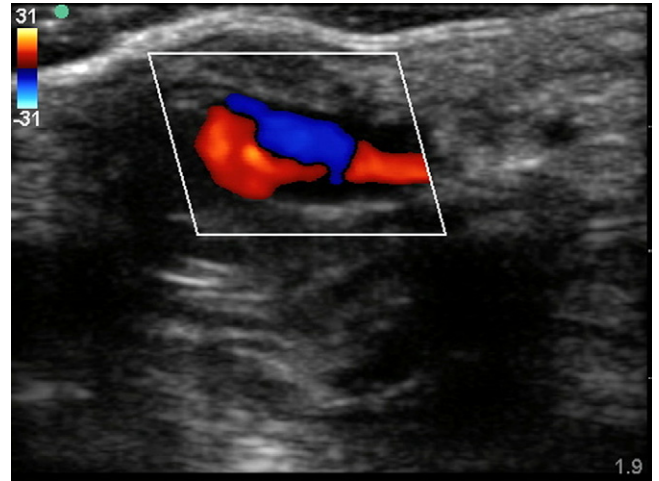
Sonographic image of the patient's pulsatile palmar mass with color Doppler flow (13-6 MHz linear-array transducer).
